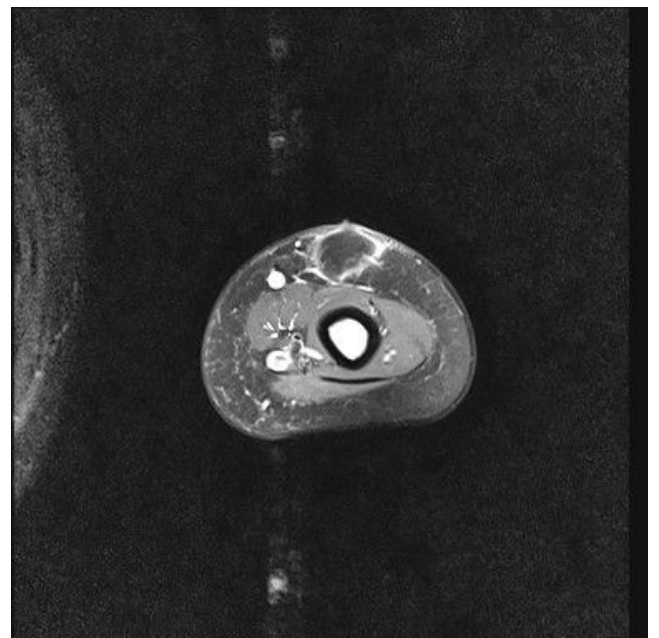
(A): MRI at diagnosis: left arm
